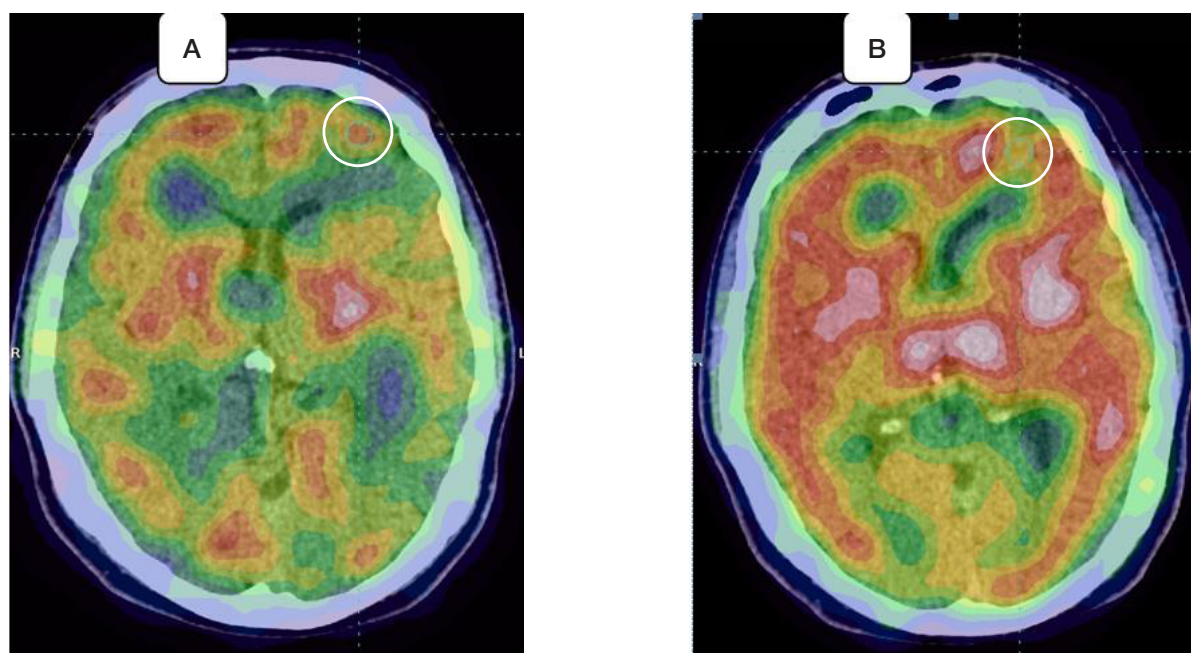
SPECT perfusion maps (RPA ^{99m}Tc -Teoxim) of the patient with refractory epilepsy performed in ictal (A) and interictal (B) phases. The annular area in the left middle frontal gyrus marks the zone of hyperperfusion in the images obtained during the ictal phase that corresponds to the hypoperfusion zone in the images obtained during the interictal phase
